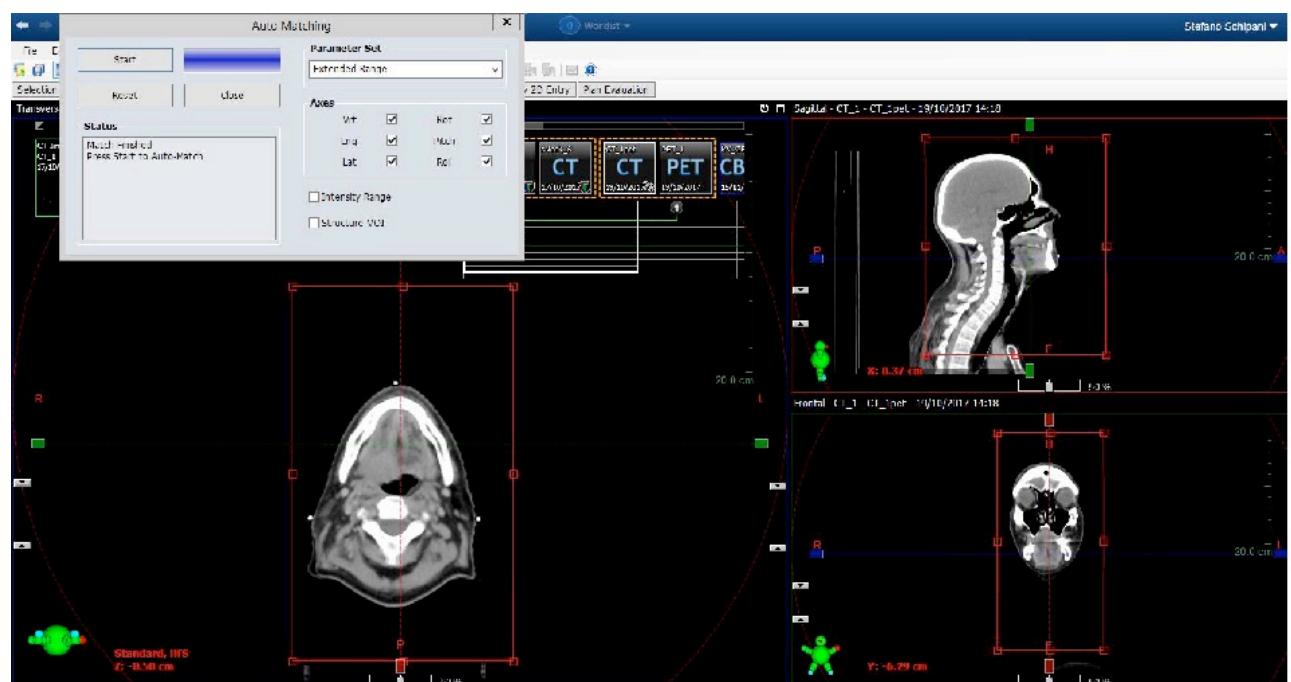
H&N PET/CT DICOM transfer from PACS into the radiotherapy treatment planning system (Eclipse, Varian). (a) PET/CT was acquired with flat table (FT), head rest (HR) and thermoplastic mask (M). The anatomical details of the CT component are visible in (b). The PET component clearly visualised the right base of tongue cancer in this patient.
